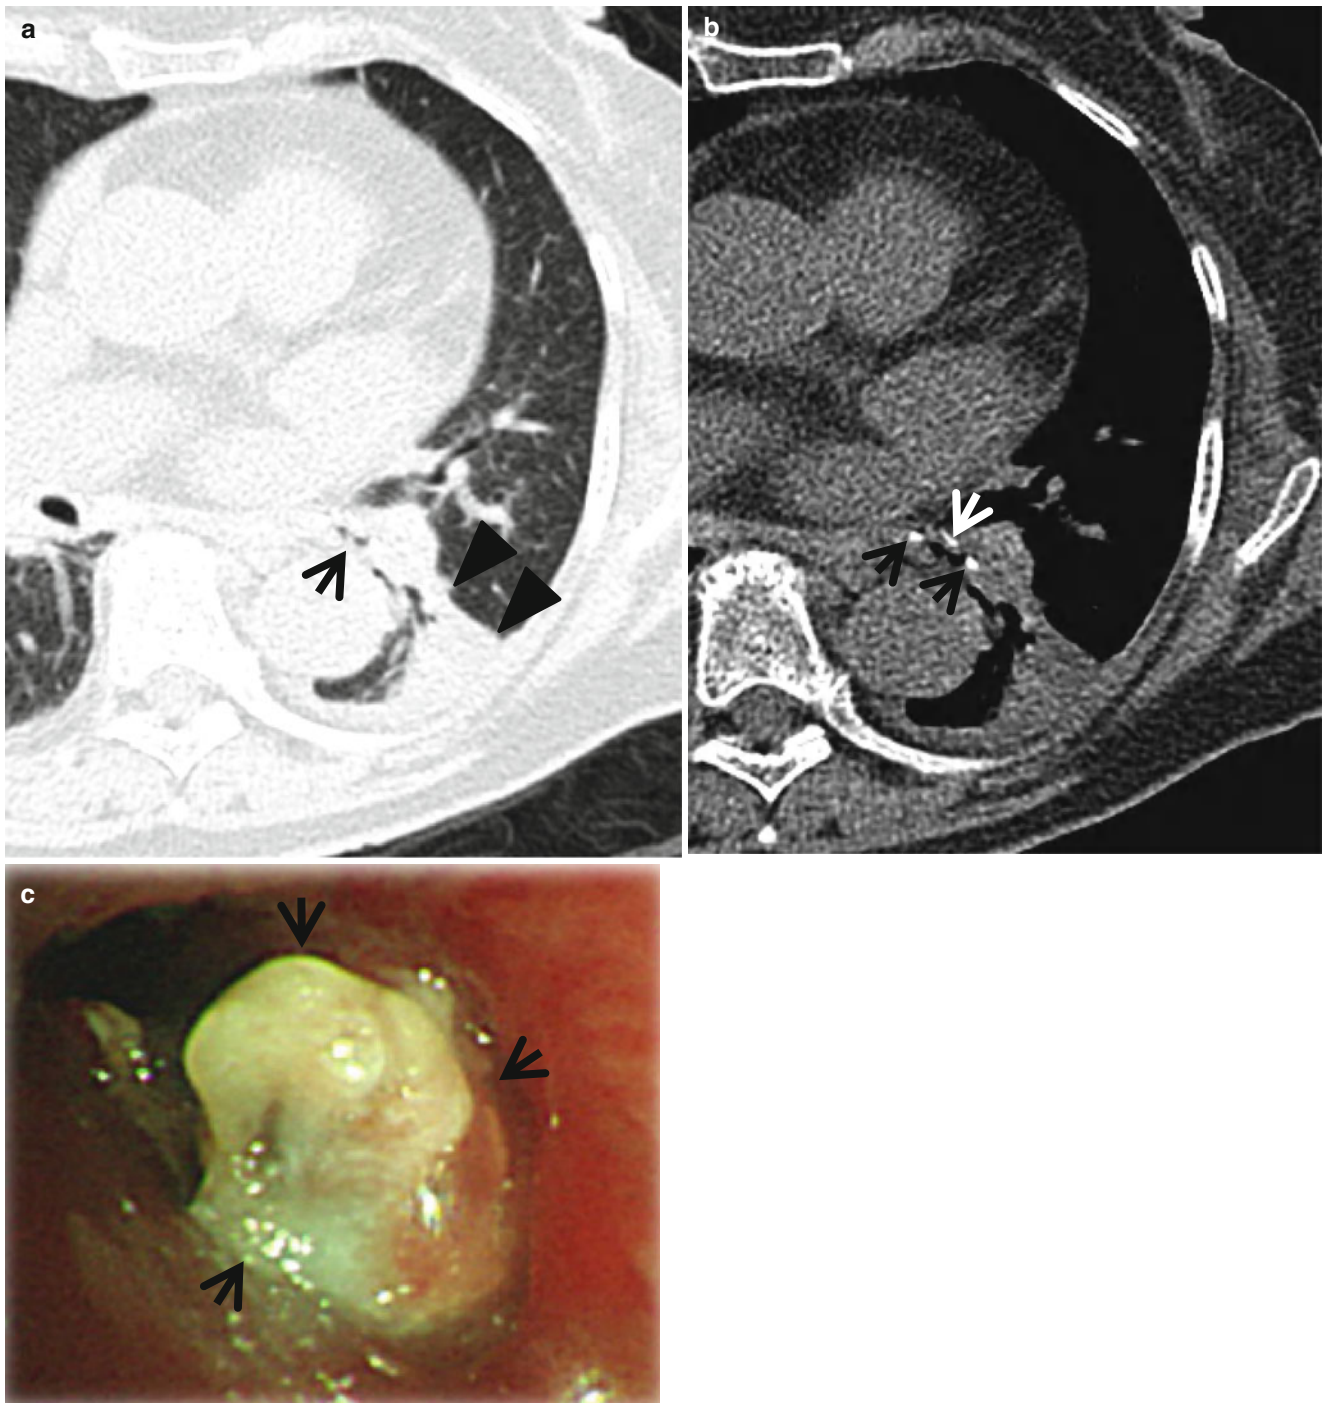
Left lower lobar atelectasis related to aspirated foreign body in an 82-year-old woman. (a) Lung window of CT scan (2.5-mm section thickness) obtained at the left lower lobar bronchus level shows the narrowed left lower lobar bronchus (*arrow*) and volume decrease of left lower lobe bounded laterally by left major fissure (*arrowheads*). (b) Mediastinal window image demonstrates peribronchial calcific attenuations (*arrows*) that are associated with left lower lobar bronchial
